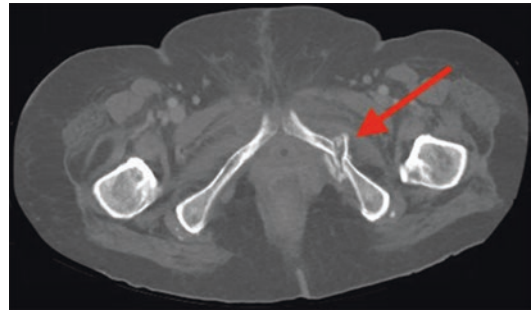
Axial CT through the lower pelvis with bone reformats shows a fracture of the left interior pubic ramus (red arrow) with a surrounding high density haematoma
